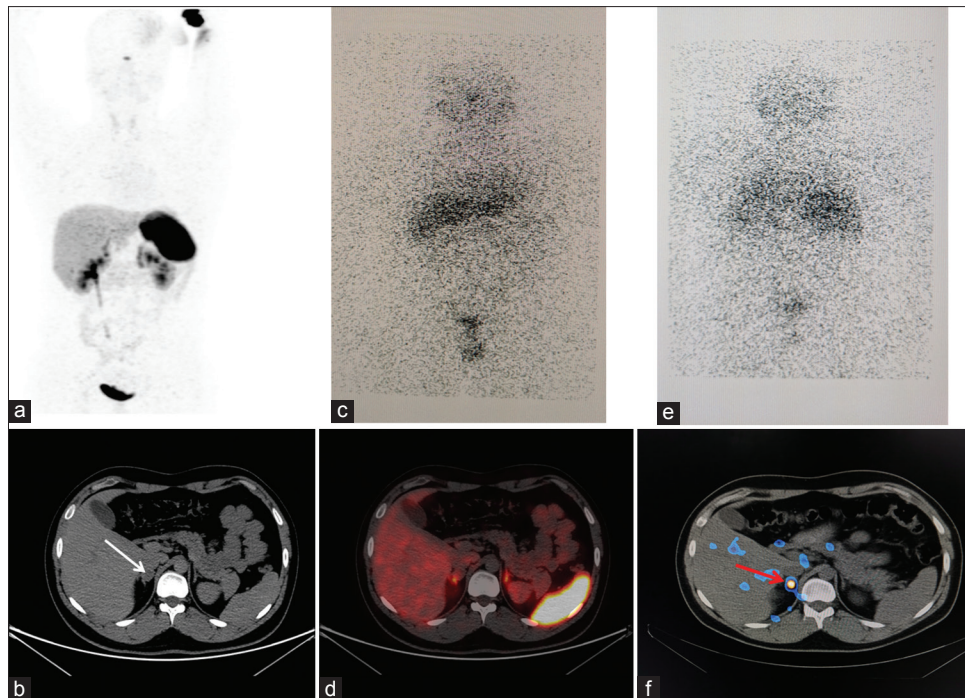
(a) Maximum intensity projection images of ⁶⁸Ga DOTANOC positron emission tomography-computed tomography showing no abnormality. (b) Transaxial computed tomography scan showing nodule in the body of right adrenal (solid white arrow). (c) Planar image of the ¹³¹I-MIBG (anterior view) showing no pathological foci of radiotracer uptake. (d) Fused transaxial ⁶⁸Ga DOTANOC positron emission tomography-computed tomography image showing no somatostatin receptor expression in the right adrenal body nodule. (e) Normal planar image of the ¹³¹I-MIBG (posterior view). (f) Fused transaxial ¹³¹I-MIBG single photon emission computed tomography-computed tomography image showing MIBG accumulation in the right adrenal body nodule
